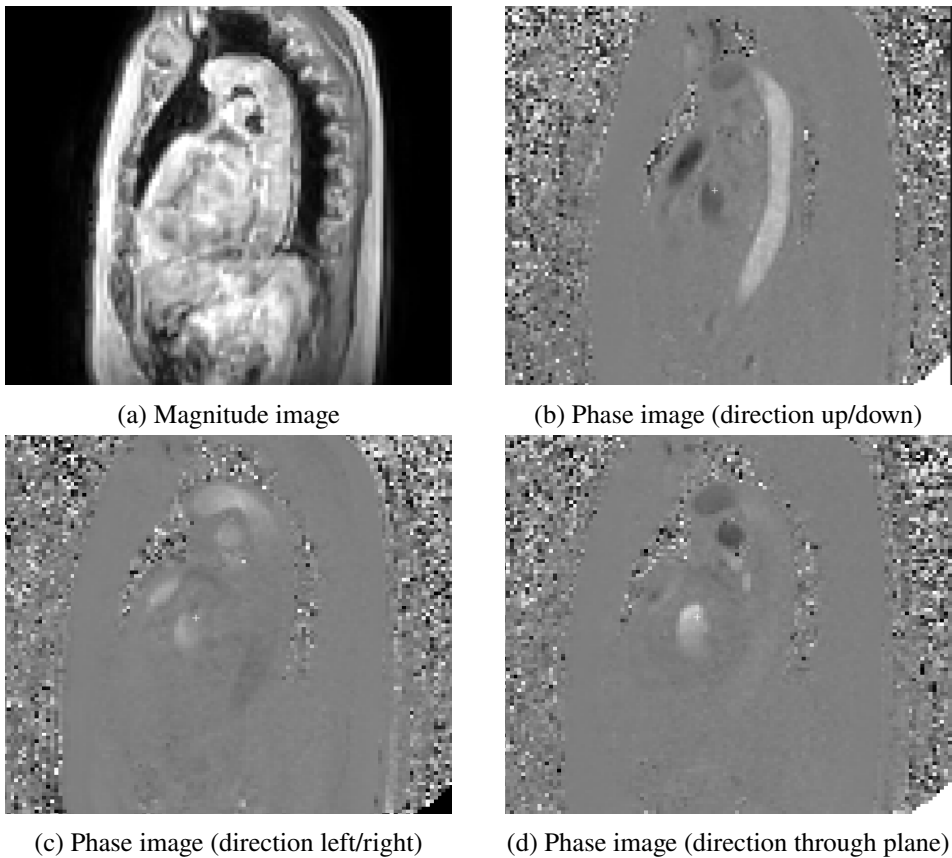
4D PC MRI magnitude and phase images.
